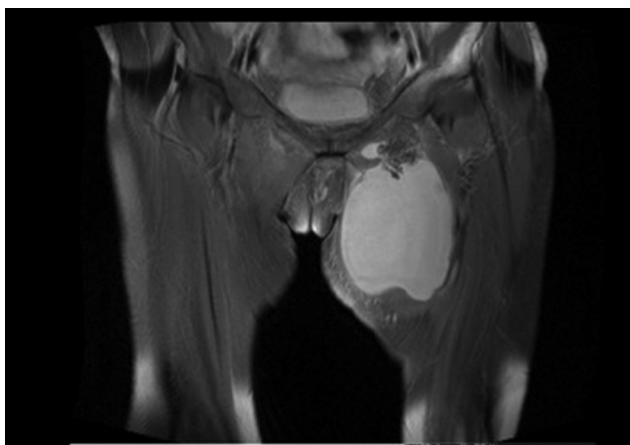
Coronal fat saturated T2-weighted MR image.
